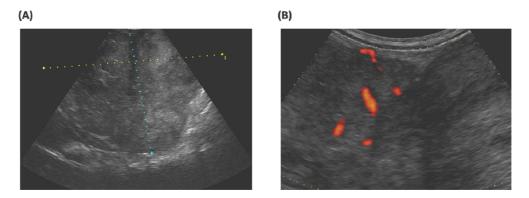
Abdominal ultrasonography of the mass. Note a heterogeneous mass $(10 \times 9 \text{ cm})$ with an irregular border (A). On the color Doppler examination (B), the mass shows blood flow signal.
